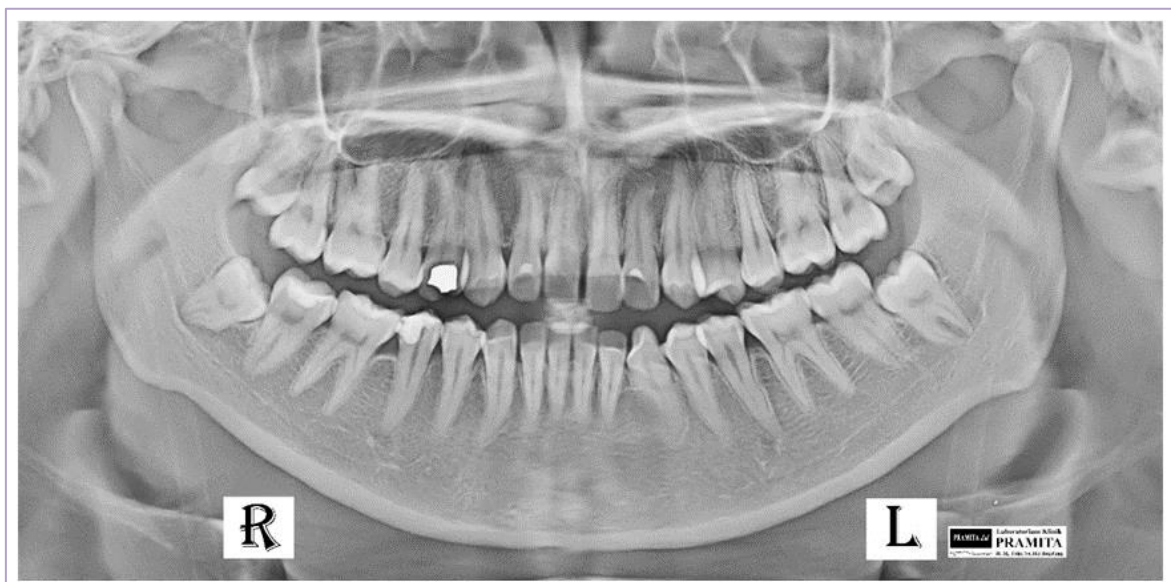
Panoramic radiograph of the patient before orthodontic treatment
